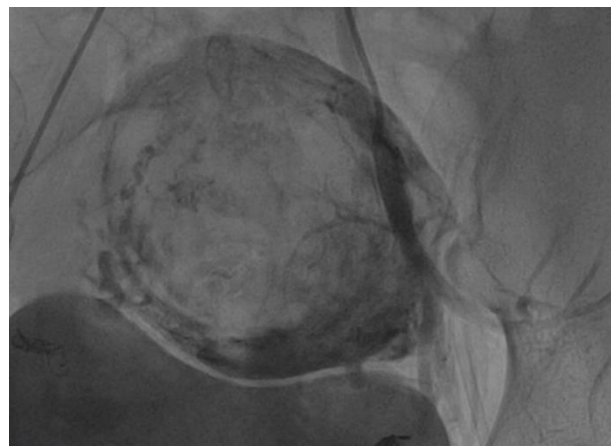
Post uterine artery embolization of CT angiogram.
